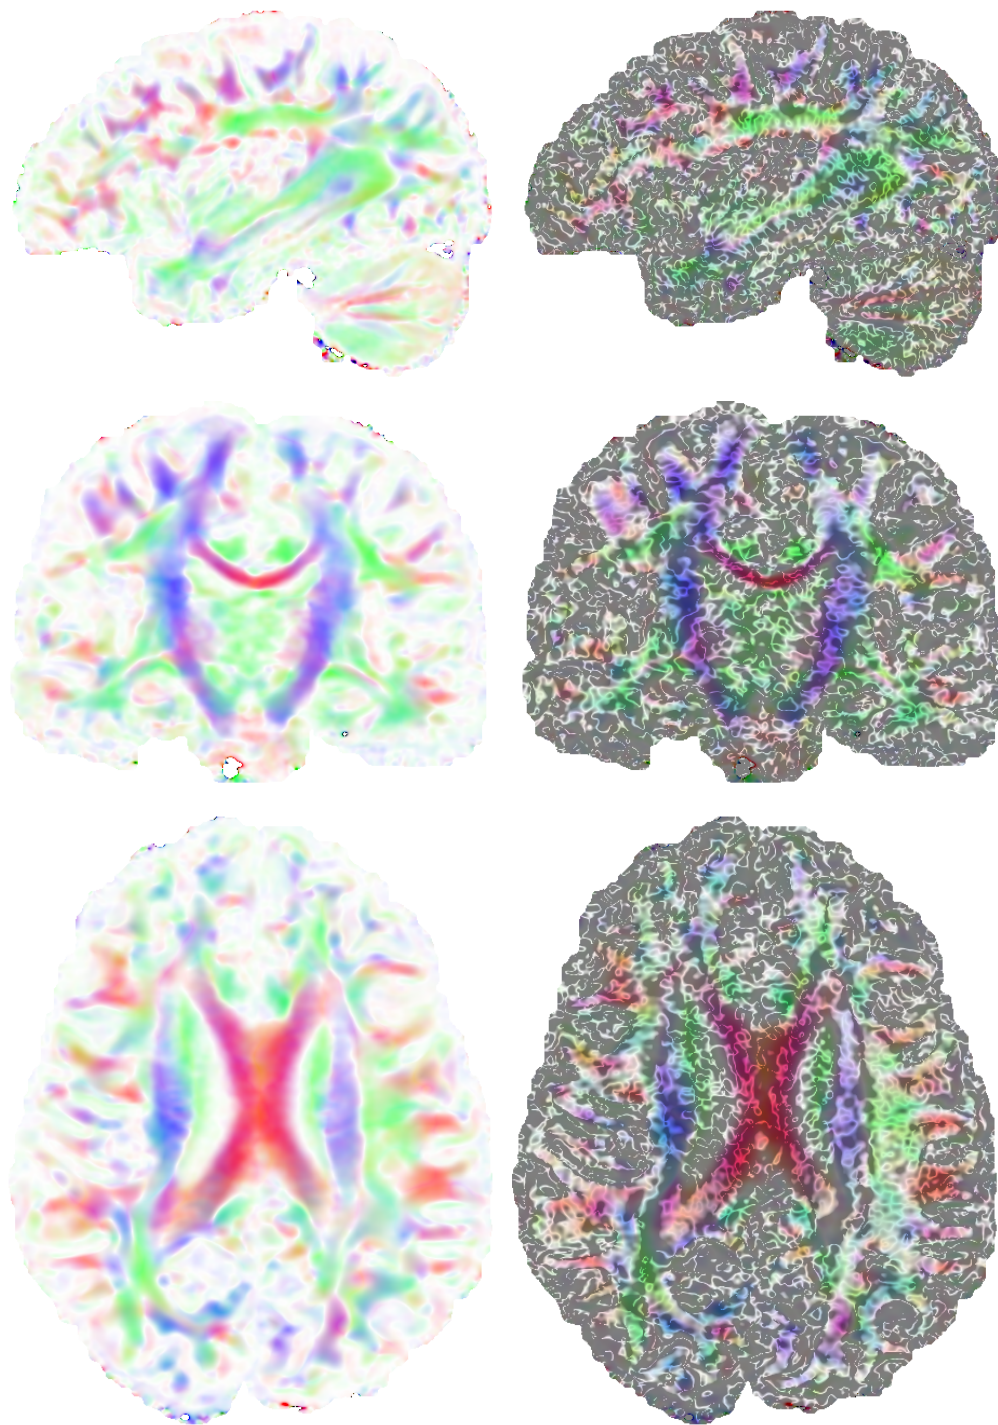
In the left column, standard XYZ-RGB color maps of the principal eigenvector are shown for three orthogonal slices of a DT-MRI dataset. In the right column, the absolute value  $|\zeta|$  of our nonintegrability measure is overlaid in black (transparent if  $|\zeta| = 0$ ,  $\alpha = 0.5$  for  $|\zeta| \geq 0.1$ ). Even though  $|\zeta|$  masks out several regions where we cannot expect to integrate meaningful streamsurfaces, substantial regions remain in which streamsurfaces can be used for visualization.
